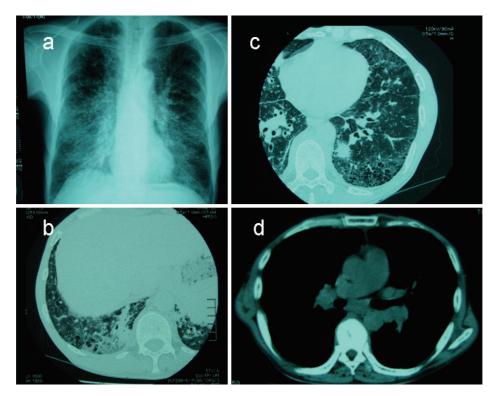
A chest radiograph shows hyperinflation and reticular and linear shadows in bilateral lung fields (a). High-resolution computed tomography of the chest demonstrates multiple consolidations (b), nodules (c), and a subpleural curvilinear shadow (c), in addition to ground-glass opacities and emphysema. A pleural plaque and swelling of hilar and mediastinal lymph nodes are also observed (d).
